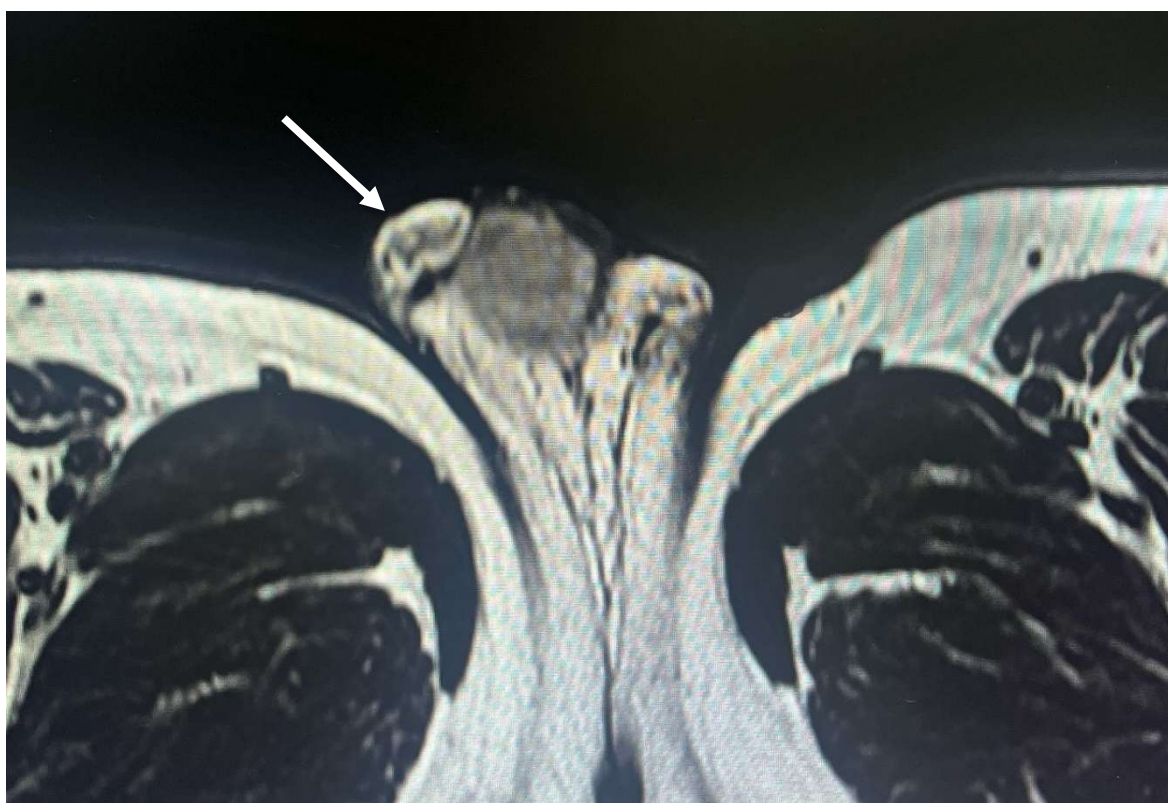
Axial T2-weighted magnetic resonance image of the scrotum showing a heterogeneously hyperintense paratesticular mass located superior to the right testis. The lesion demonstrates high signal intensity and remains clearly separated from the testicular parenchyma, with no evidence of invasion or associated hydrocele. On post-contrast
